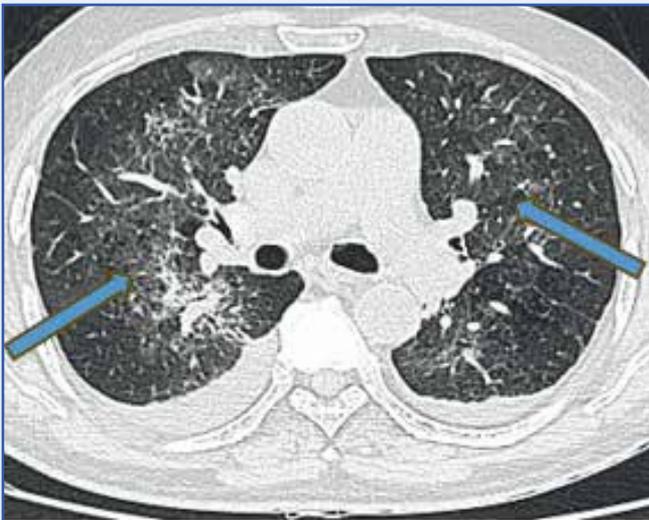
HRCT chest axial image significant resolution of bilateral consolidations (blue arrows)
